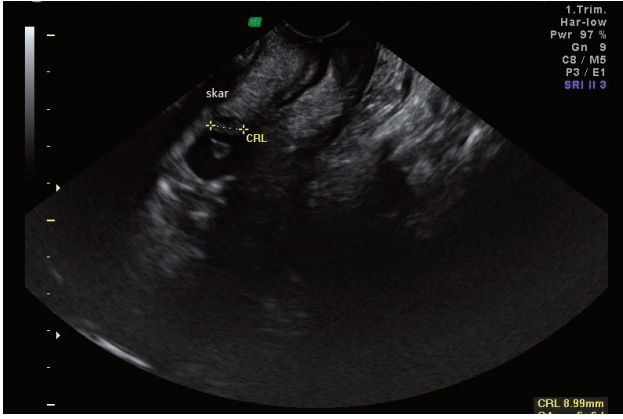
Crown-rump length (CRL) of the CSP in Case 8 is marked on ultrasonographic view.
